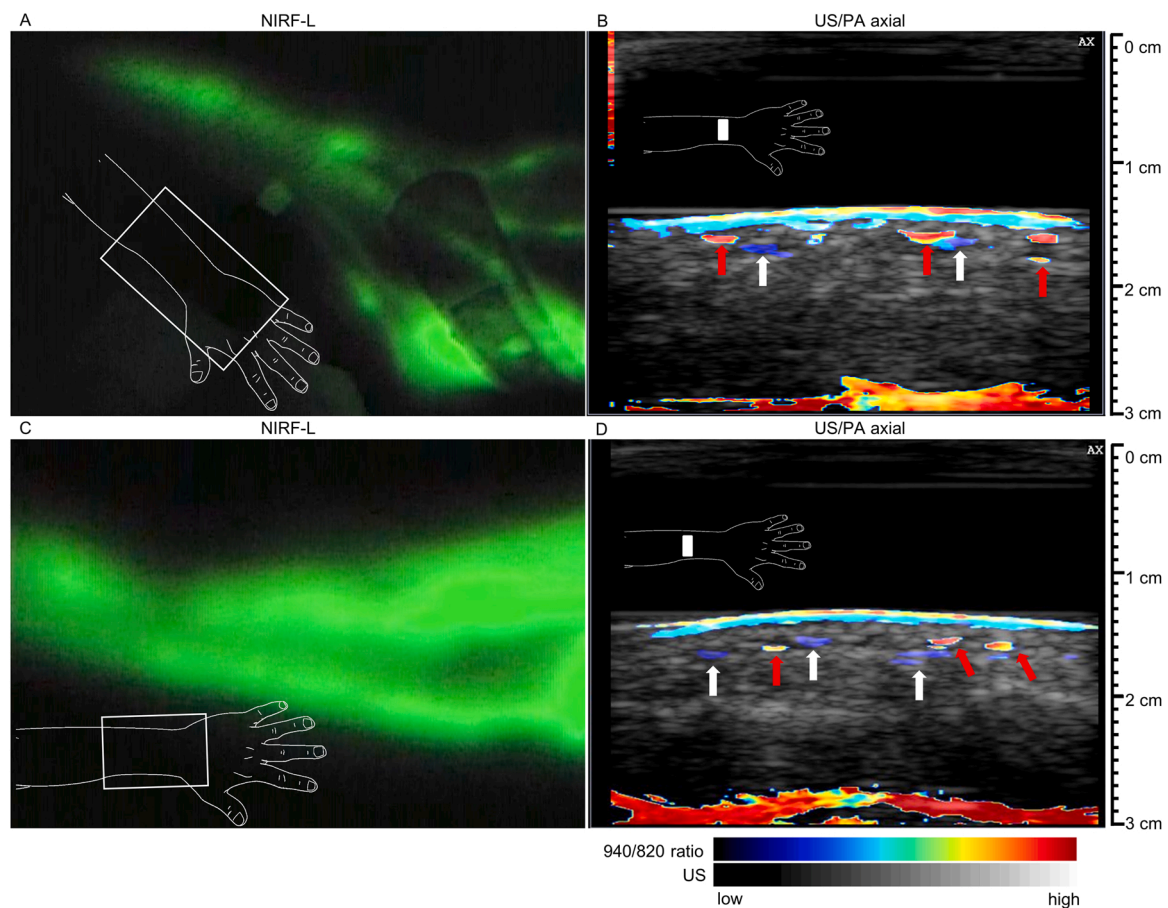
Near-infrared fluorescence lymphography (NIRF-L) images (A and C) with linear patterns in a healthy arm (A) and lymphedema arm (C). B and C represent photoacoustic (PA) images of 940/820 nm ratio superimposed on grayscale ultrasound (US) images of the corresponding NIRF-L regions. Red arrows indicate blood vessels and white arrows indicate lymphatic vessels. More lymphatic vessels were observed with PA imaging compared to NIRF-L. Reflection artefacts originating from the skin surface can be observed at a depth of ~3 cm.
